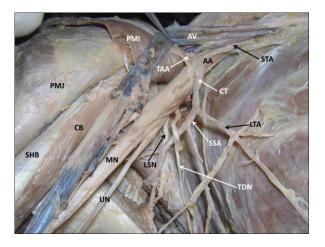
Dissection of the right axilla showing the variant common arterial trunk (CT) from axillary artery (AA – axillary artery; AV – axillary vein; STA – superior thoracic artery; TAA – thoracoacromial artery; PMJ – pectoralis major; PMI – pectoralis minor; SHB – short head of biceps; CB – coracobrachialis; MN – median nerve; UN – ulanar nerve; LSN – lower subscapular nerve; TDN – thoracodorsal nerve; SSA – subscapular artery; LTA – lateral thoracic artery).
